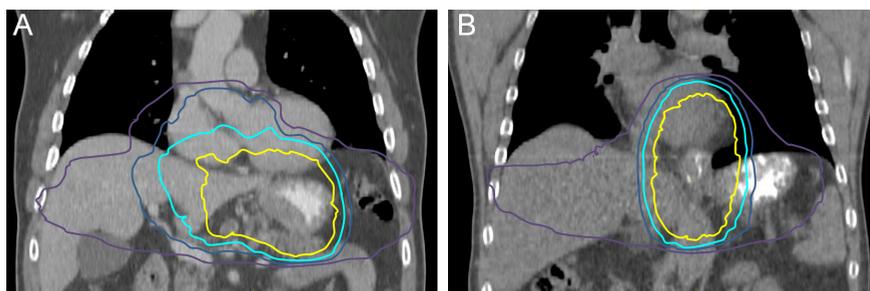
Examples of treatment planning CT scans with dose distributions in (A) a patient who developed postoperative anastomotic leakage after receiving a mean dose to the gastric fundus of 41.2 Gy, and in (B) a patient who did not experience postoperative anastomotic leakage after receiving a mean dose to the gastric fundus of 11.8 Gy. The areas within the yellow, light blue, dark blue and purple lines received at least 40, 30, 20, and 10 Gy, respectively.
